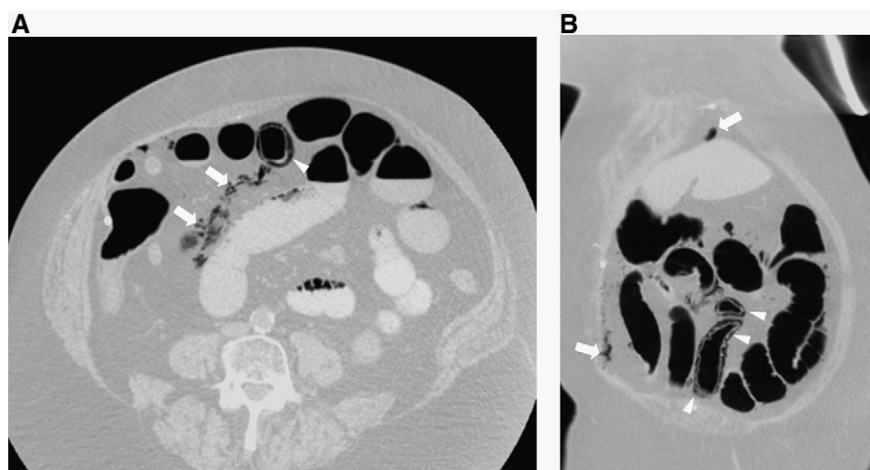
Incidental detection of pneumatosis intestinalis in a patient treated with the tyrosine kinase inhibitor sunitinib for recurrent renal cell carcinoma. (A) Axial computed tomographic abdominal images, showing evidence of air within the small bowel wall (arrowhead). The air dissects through the walls into the adjacent mesentery (arrows). Note normal adjacent air and contrast-filled bowel loops. (B) The coronal computed tomography images, showing pneumatosis intestinalis (arrowheads) and free intraperitoneal air (arrows).
